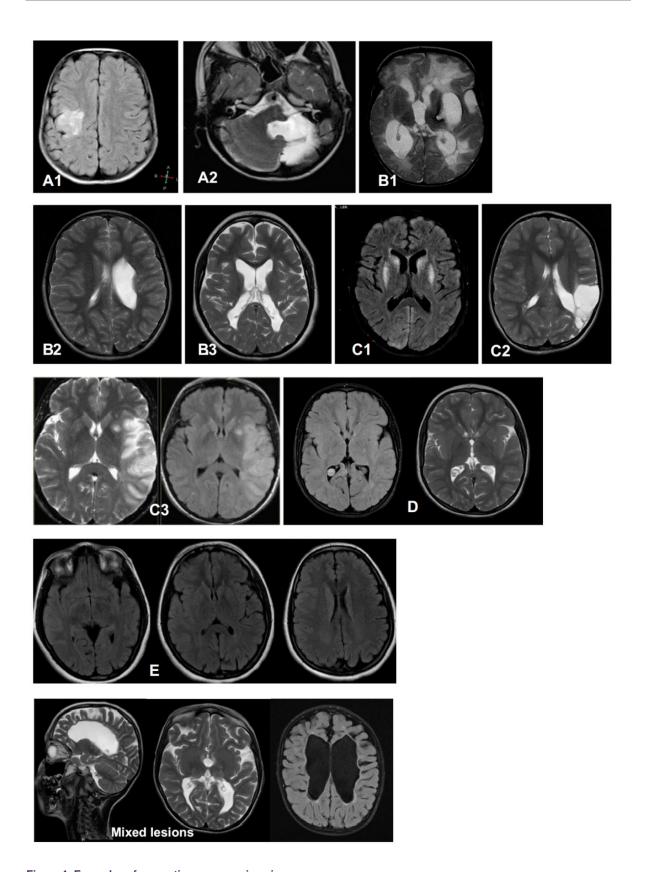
Examples of magnetic resonance imaging
